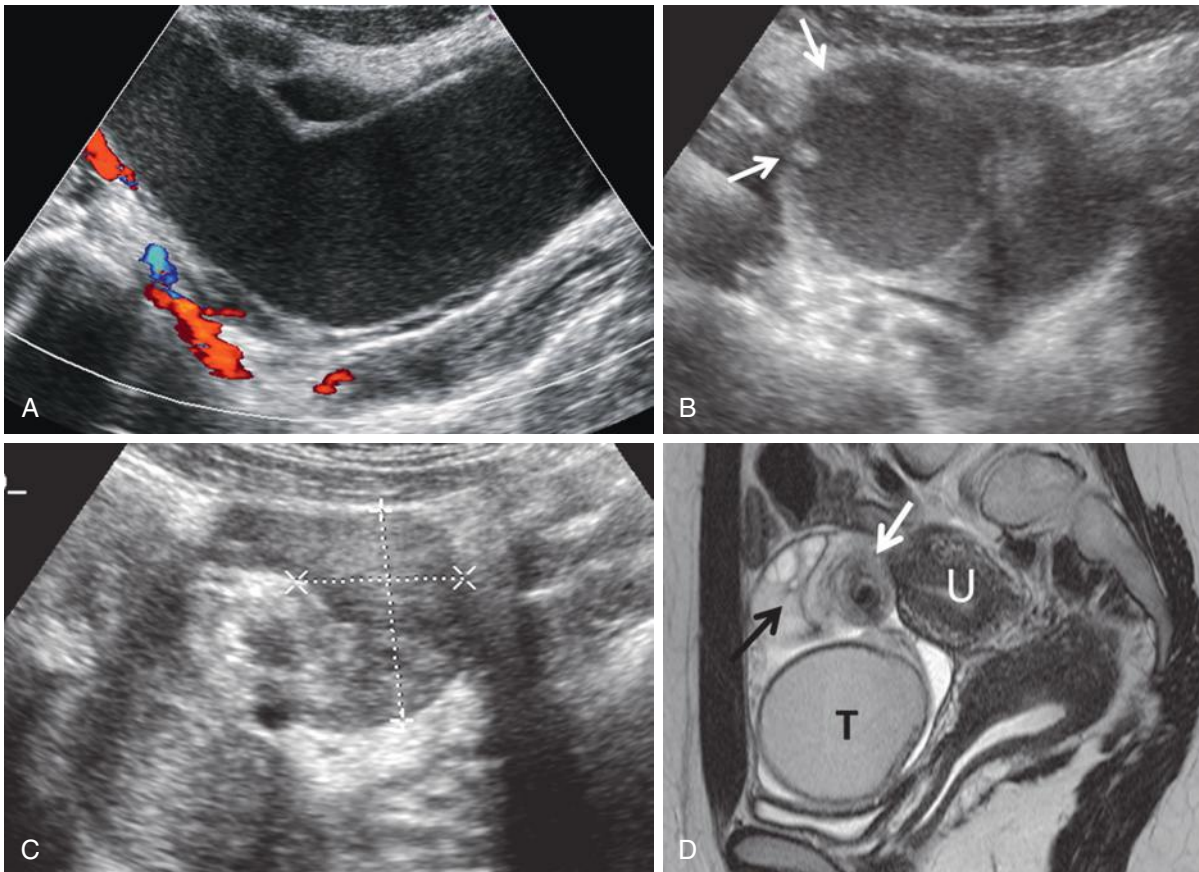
Isolated fallopian tube torsion. A, Color Doppler image shows tubular structure filled with complex fluid and no blood flow, corresponding to hematosalpinx. B, On cross section, the endosalpingeal folds (*arrows*) are visualized. C, The left ovary (*calipers*) was normal in size and echotexture and had normal blood flow (not shown). D, Sagittal T2-weighted magnetic resonance image shows the site of the twist (*white arrow*), the normal left ovary (*black arrow*), and the blood-filled dilated fallopian tube (T) anterior to the uterus (U).
